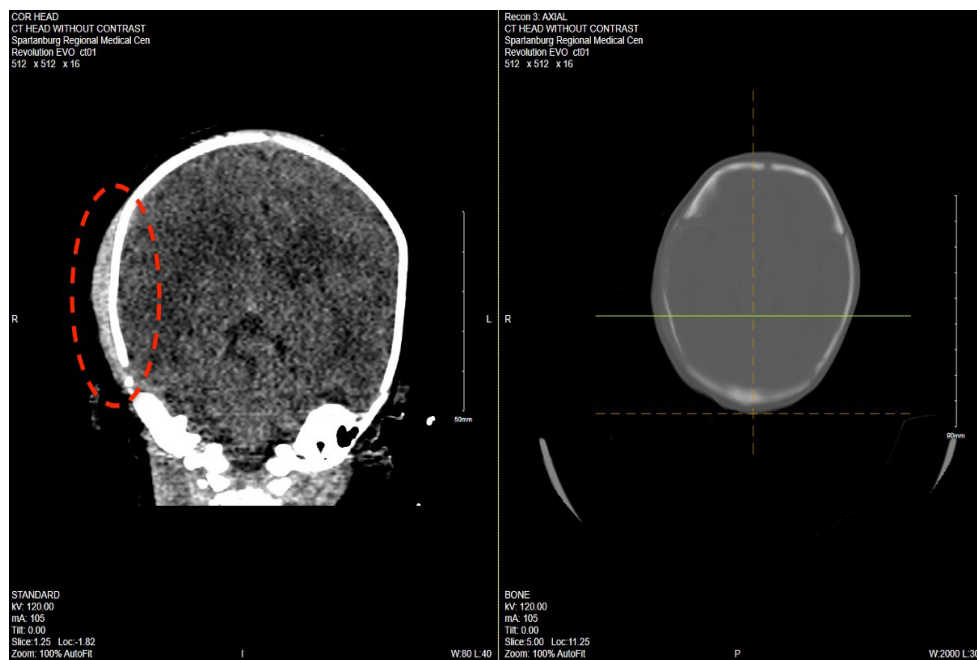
CT of cephalohematoma.
